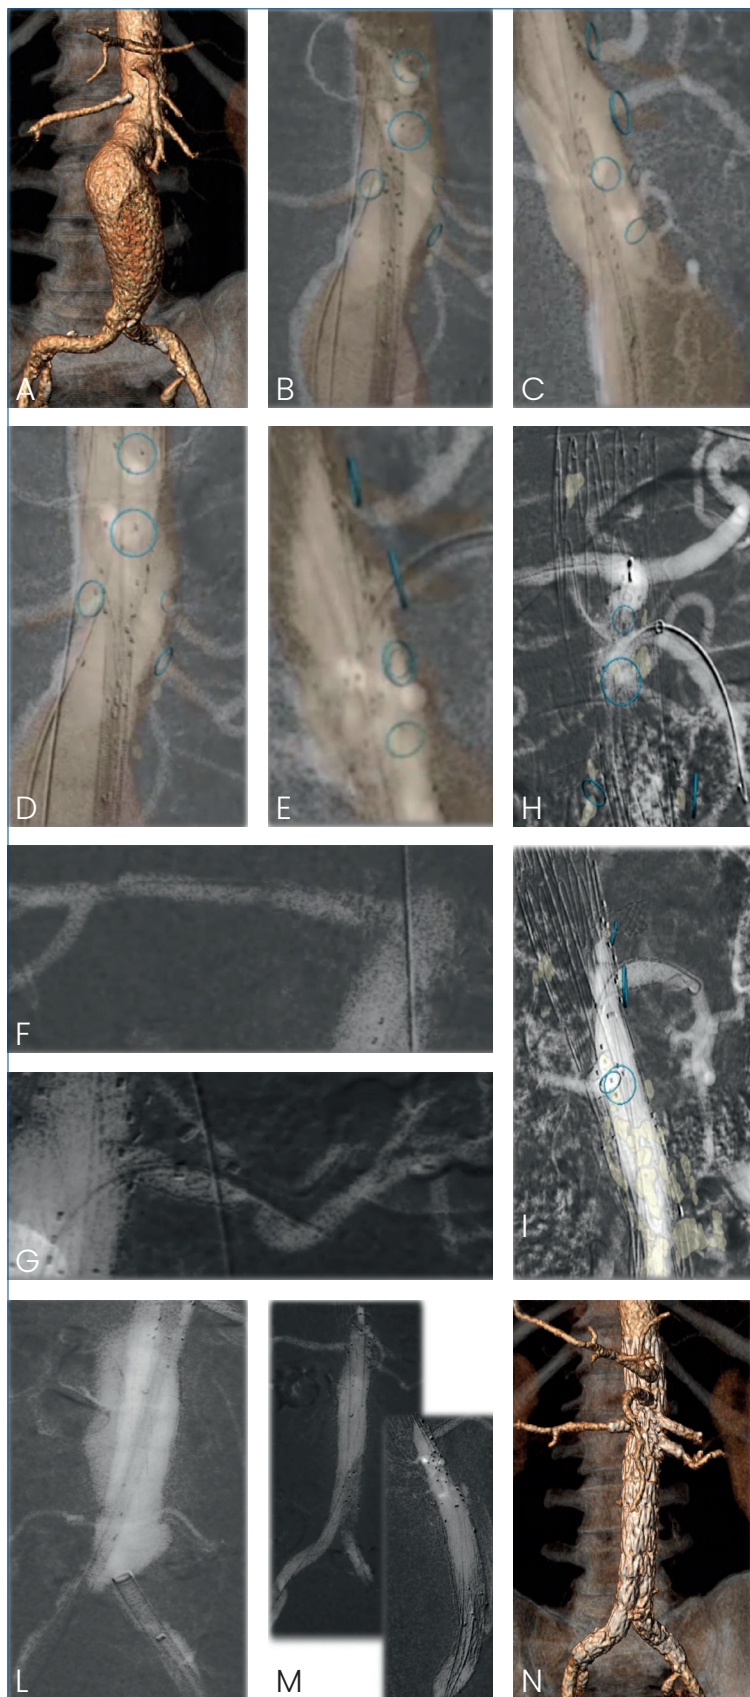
● Technical aspects of the implantation of a 5-fenestration custom-made endograft (FEVAR) using synergic application of fusion imaging and CO₂-DSA. A) Pre-operative computed tomography evaluation in three-dimension volume rendering of the juxtarenal aneurysm; B) anterior posterior CO₂-DSA and adjustment of the fusion imaging for renal arteries (RA); C) lateral view CO₂-DSA and adjustment of the fusion imaging for superior mesenteric artery (SMA) and celiac trunk (CT); D, E) deployment, opening of the endograft following step by step fusion imaging guidance and CO₂-DSA and cannulation of the target vessels with diagnostic introducer outside the main body endograft; F) selective CO₂-DSA of right RA after stenting with diagnostic introducer inside the target artery; G) selective CO₂-DSA of lower left RA after stenting with diagnostic introducer inside the target artery; H) selective CO₂-DSA of CT after stenting with diagnostic introducer inside the main body endograft; I) selective CO₂-DSA of SMA after stenting with diagnostic introducer inside the main body endograft; L) CO₂-DSA of the abdominal aorta and positioning of distal bifurcated universal body and iliac limbs; M) final CO₂-DSA in both anterior-posterior and lateral views with diagnostic introducer inside the iliac limb artery; N) postoperative CTA with 3-D volume rendering reconstruction.
